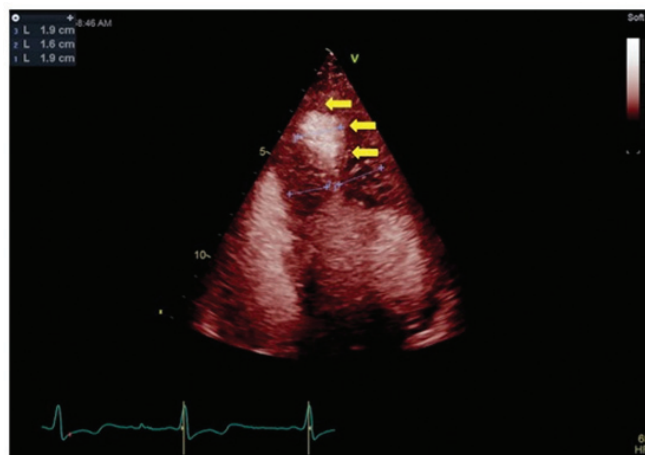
Apical 4 chamber view showing distal flow acceleration in systole (yellow arrow)
